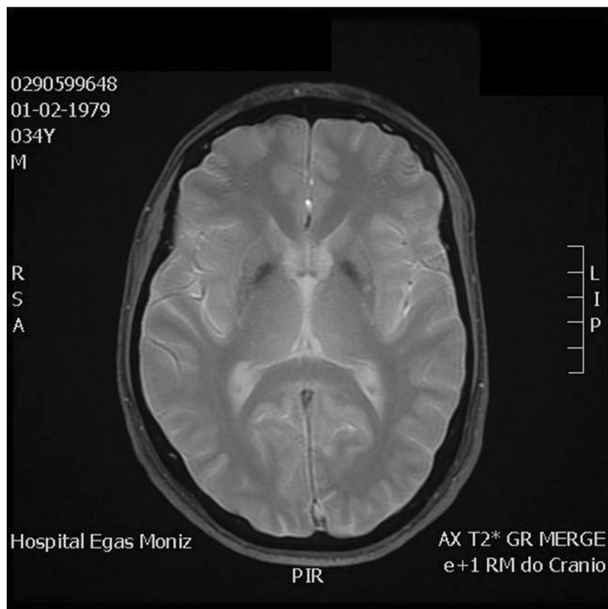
Pallidal iron accumulation with bilateral hypointensity over the globus pallidus at T2-weighted image.
